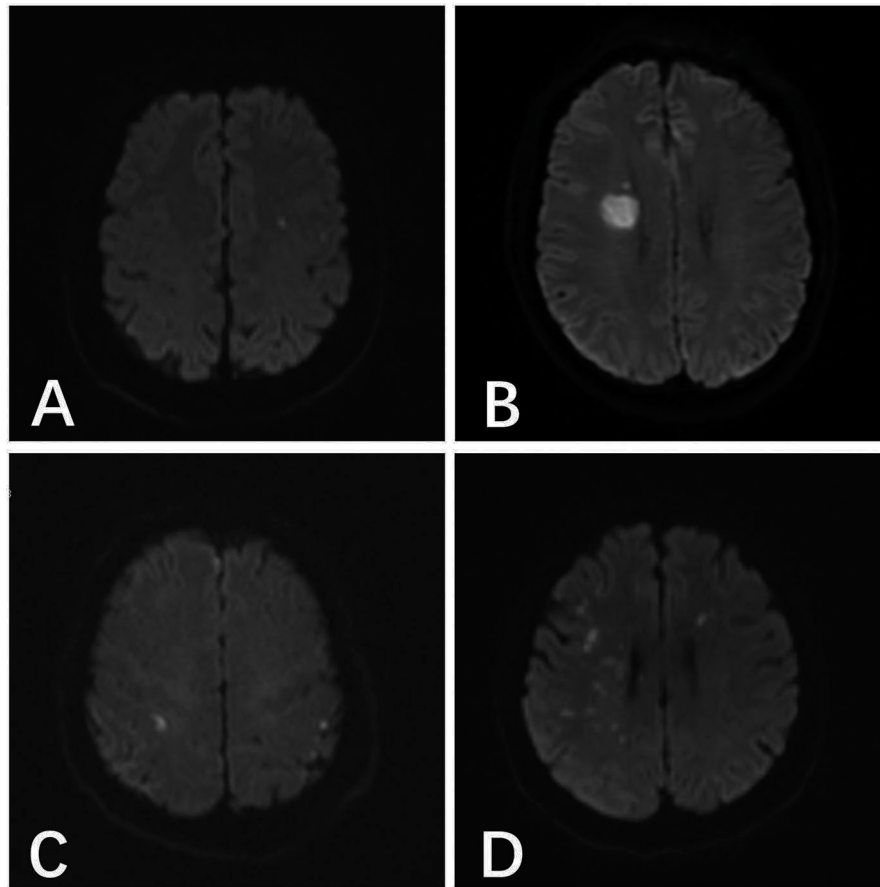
(A) A 46-year-old male patient with anterior communicating aneurysm underwent pure spring coil embolization under systemic heparinization, and the postoperative result indicated the acute cerebral infarction focus in the left parietal temporal lobe. (B) A 48-year-old male patient with right posterior communicating aneurysm underwent stent-assisted embolization under local heparinization, and the postoperative result indicated the acute cerebral infarction in the right lateral ventricle. (C) A 54-year-old male patient with right posterior communicating aneurysm underwent pure spring coil embolization under local heparinization, and the postoperative result indicated the abnormal DWI signals in the bilateral parietal lobes. (D) A 55-year-old female patient with a right middle cerebral aneurysm underwent stent-assisted embolization under systemic heparinization, the postoperative result indicated the acute cerebral infarction in the right parietal temporal lobe and the left frontal lobe.
